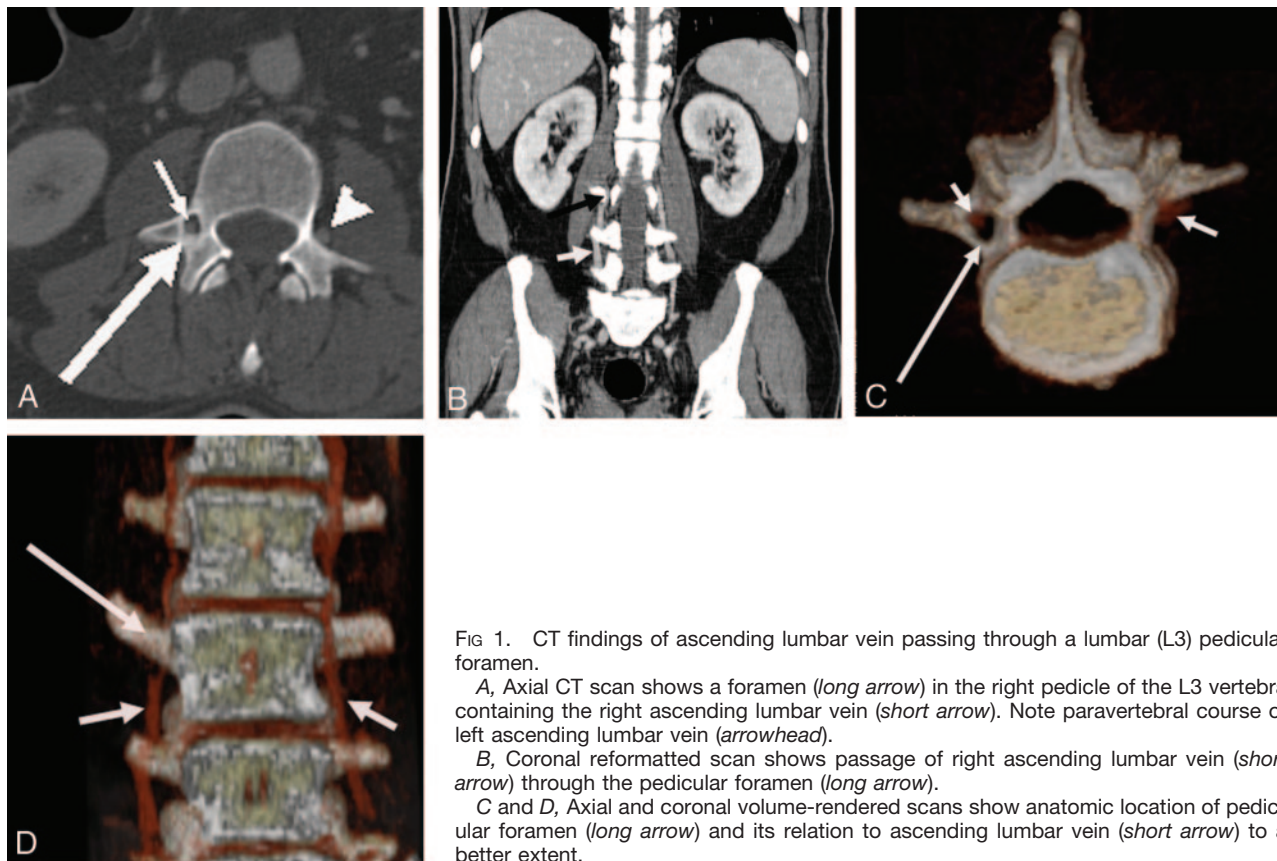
CT findings of ascending lumbar vein passing through a lumbar (L3) pedicular foramen.
